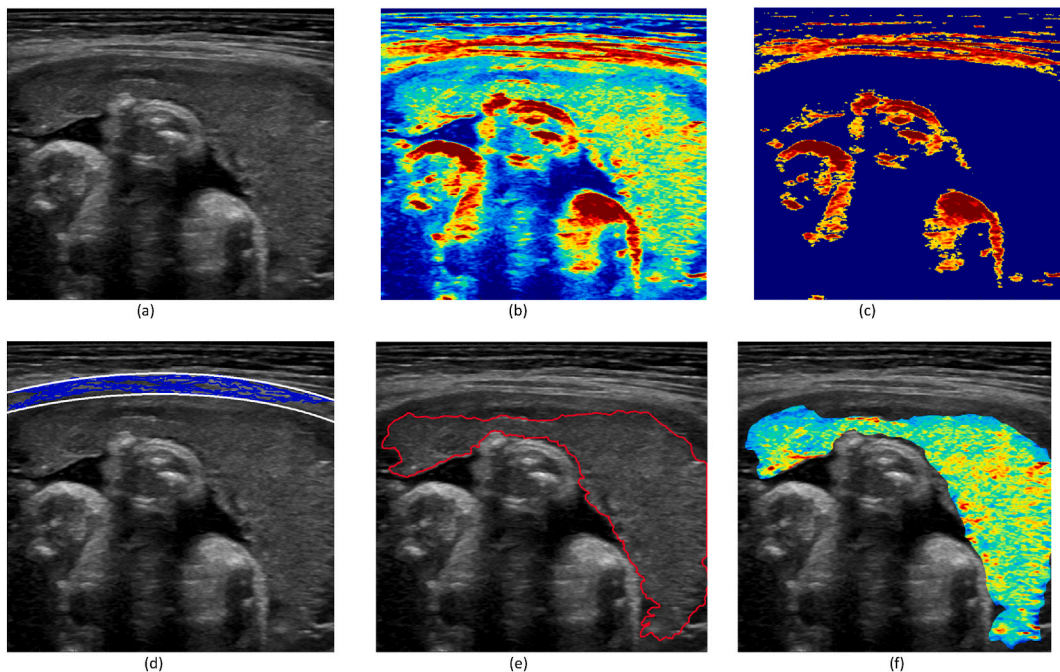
(a) The ultrasound wrapped image into the rectangular standard, (b) Daubechies wavelet filtered image, (c) thresholding for finding hard tissue, (d) result of the heuristic search for finding the uterus wall, (e) placental semantic segmentation and the guided filter results, and (f) the heatmap of placental pixel intensities.
